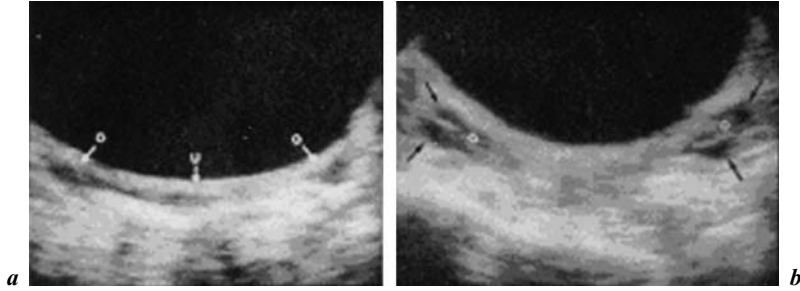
Ultrasound ovarian appearance before puberty (*a*) and after puberty onset (*b*) [from 1].
